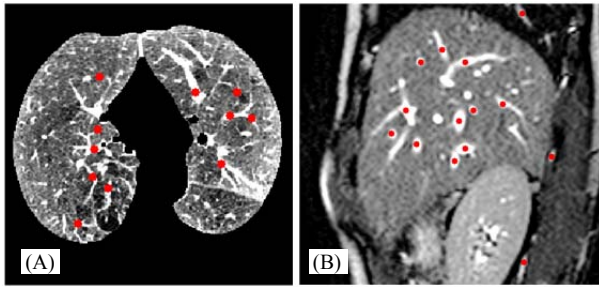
Feature tracking. Common features between maximum exhale and inhale phases, shown at maximum exhale for 4D lung CT (A) and 4D liver MRI (B), in trans-axial and sagittal slices, respectively.
